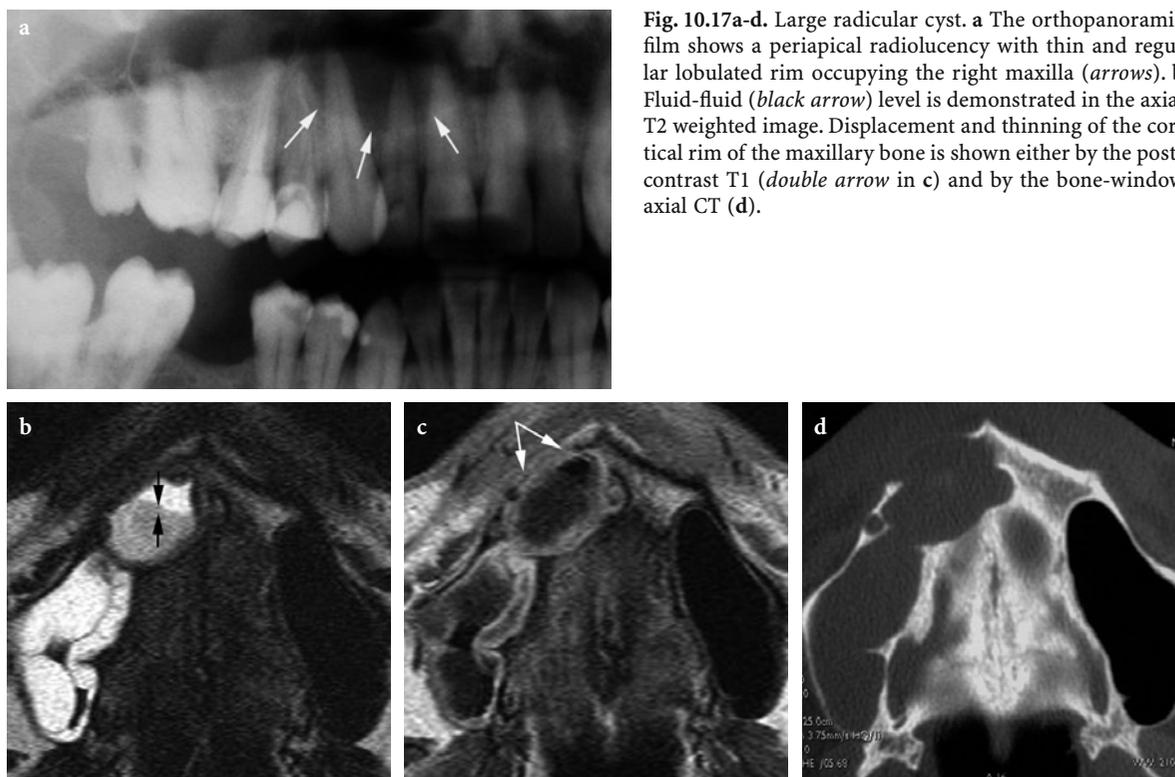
Large radicular cyst. a The orthopantomogram shows a periapical radiolucency with thin and regular lobulated rim occupying the right maxilla (arrows). b Fluid-fluid (black arrow) level is demonstrated in the axial T2 weighted image. Displacement and thinning of the cortical rim of the maxillary bone is shown either by the post-contrast T1 (double arrow in c) and by the bone-window axial CT (d).
